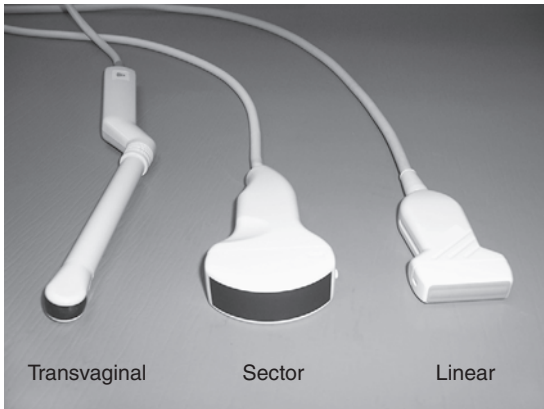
19 Ultrasound transducers. Samples of transvaginal, sector, and linear probes as labeled.
